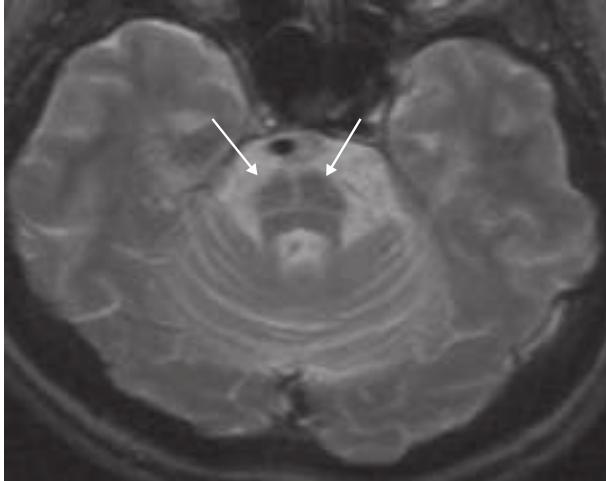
Multiple-system atrophy, cerebellar type (MSA-c). Axial T2-weighted magnetic resonance image at the level of the pons shows a characteristic hyperintense signal, the “hot cross bun” sign (arrows). This appearance can also be seen in some spinocerebellar atrophies, as well as other neurodegenerative conditions affecting the brainstem.
